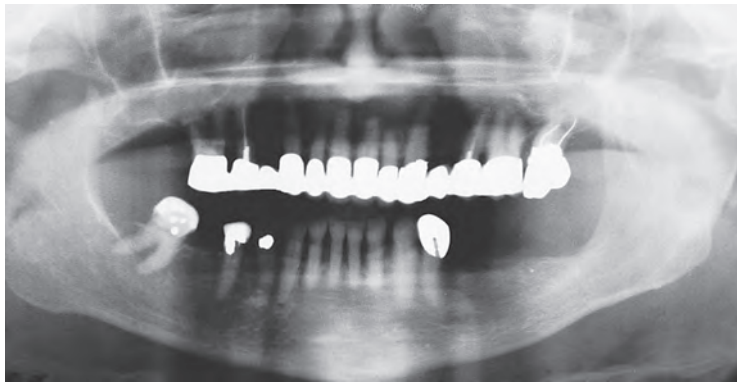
A panoramic radiograph of the mandible shows a multiloculated cystic lesion of the left-hand side of the mandible.
